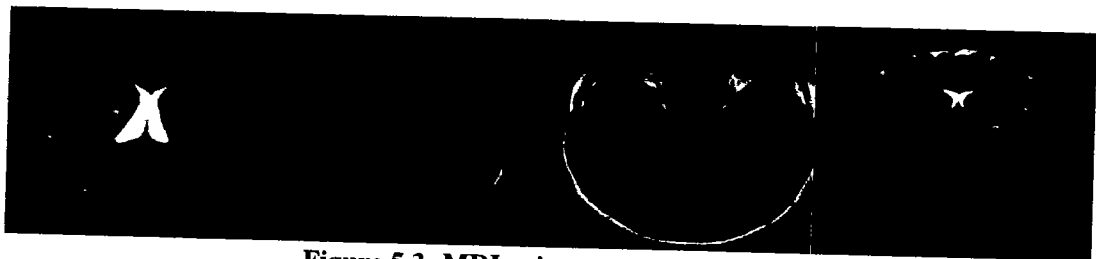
MRI prior to preprocessing
